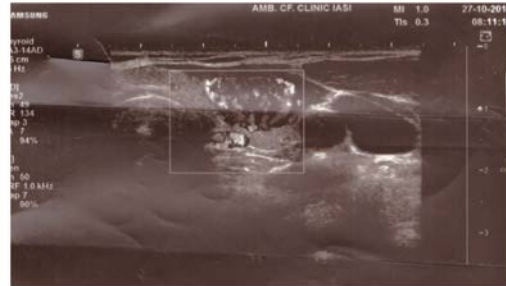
Doppler image of left thyroid lobe: the nodule with type III vascularization.
